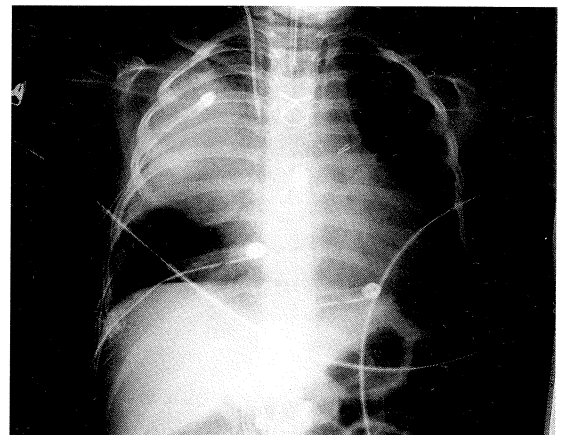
Post-operative pulmonary artery chest X-ray showing extensive right haemothorax around the site of the right pulmonary artery repair.
